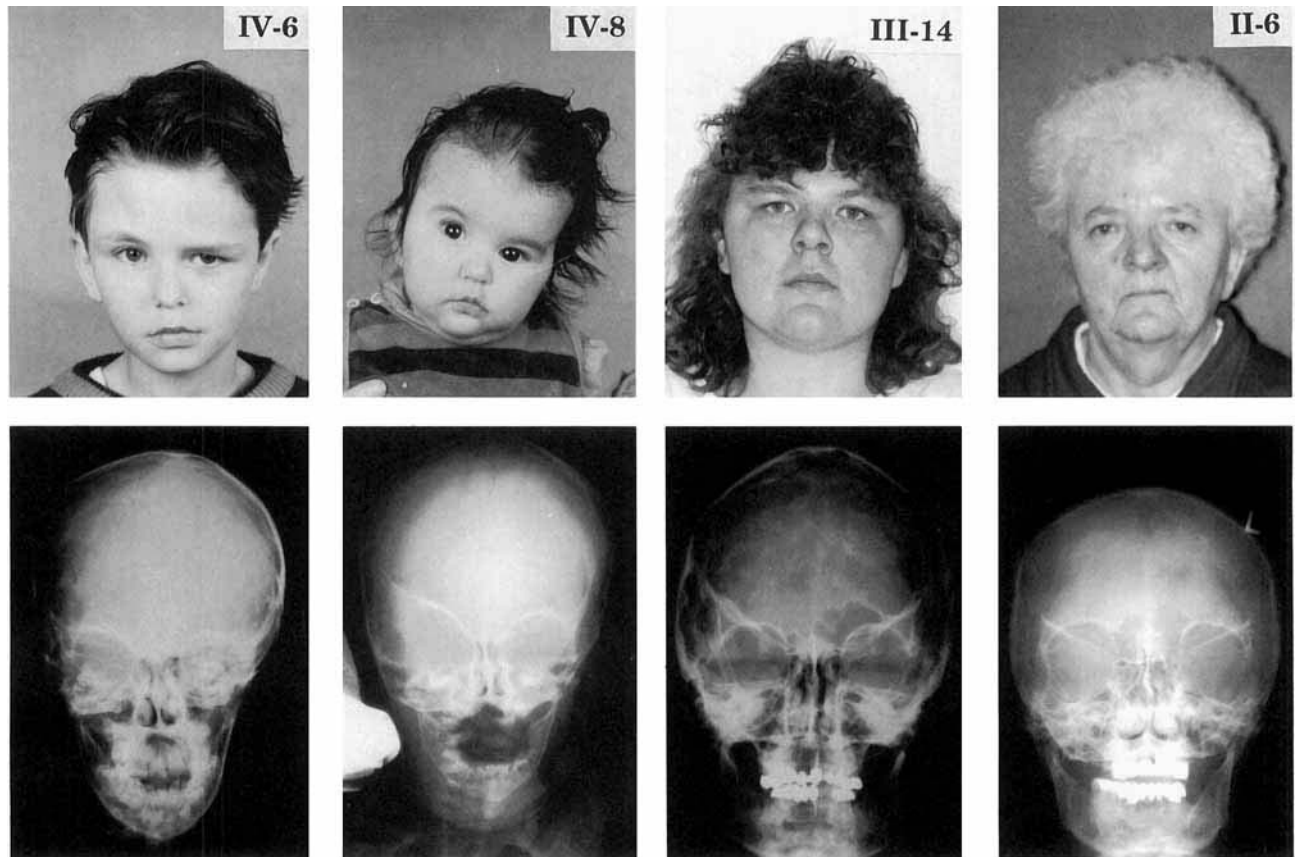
Facial appearance and a.p. radiological views of the propoiti (unilateral coronal suture synostosis) and two selected relatives (bilateral coronal synostosis). The two propoiti (IV-6, IV-8) show marked asymmetry of the face, with unilateral flattening of the forehead. These clinical findings are confirmed in the radiographic views. Individuals III-14 and II-6 have bilateral coronal synostosis and broad flattened face. In III-14 the radiograph demonstrates marked indirect signs of raised intracranial pressure (impressions digitatae), and virtual absent development of the right frontal sinus
